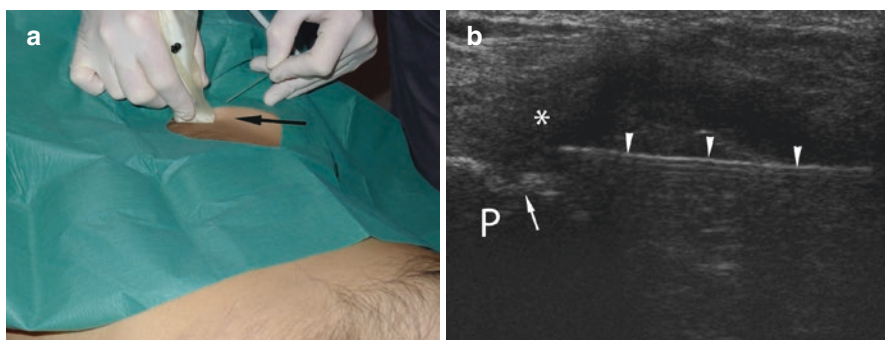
(a) Operator scanning transversely in aseptic field at lateral symphysis pubis having marked the lateral end of the probe with needle entry (*arrow*) into the unmarked skin between the mark and probe. (b) Transverse ultrasound image shows the pubis (P) with normal cortical irregularity (*arrow*). Using a lateral approach, the needle (*arrowheads*) is within the hypoechoic capsular and adductor tissues (*)
